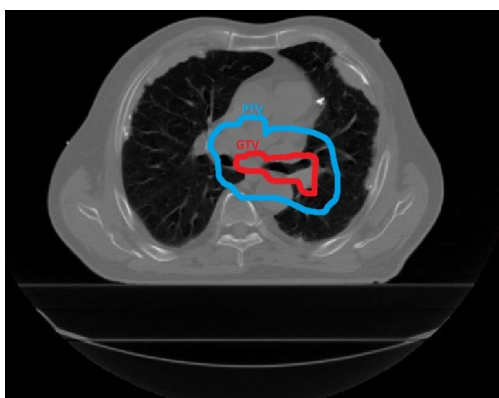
Lung tumour state during RT for Patient 34: This patient had two different planning-CTs with their relevant GTV on each scan as the patient suffered from collapsed lung during RT. This figure shows different fractions of CBCT with respect to the GTV of their relevant CT.
